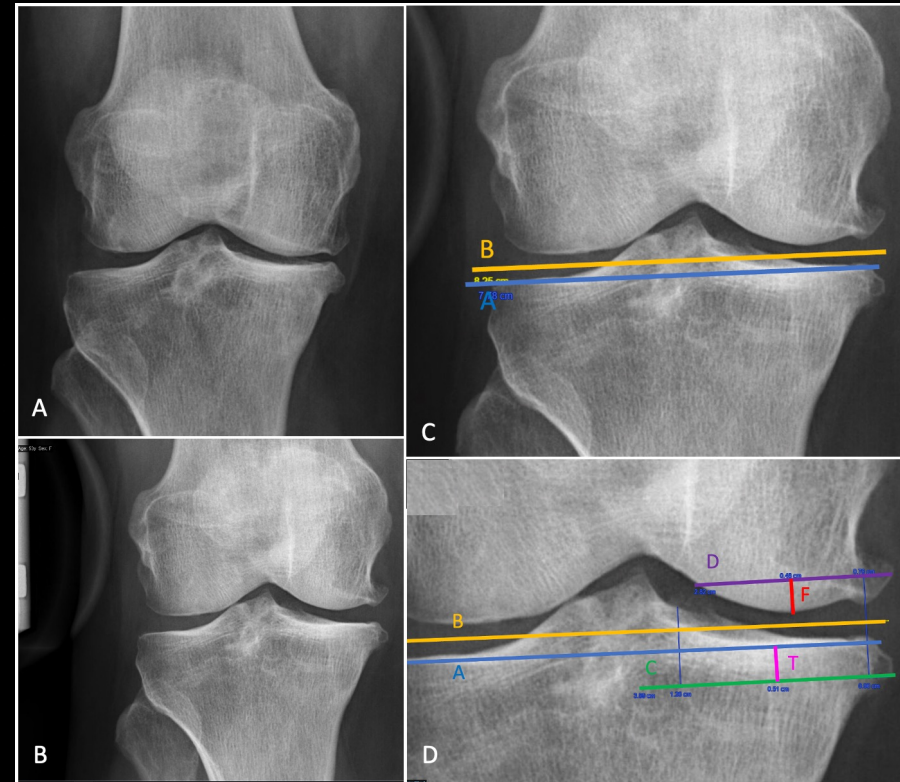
Another example of the preoperative medial UKA planning method done with valgus stress x-rays.
